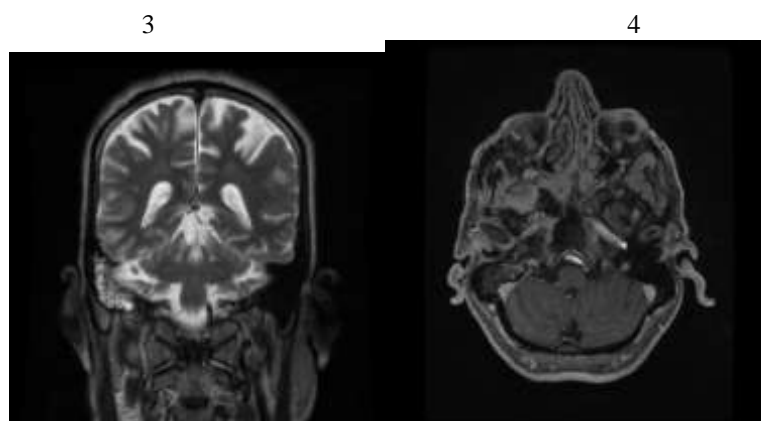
Right Cavernous sinus is widened showing enhancement of soft tissue component on Contrast MRI
